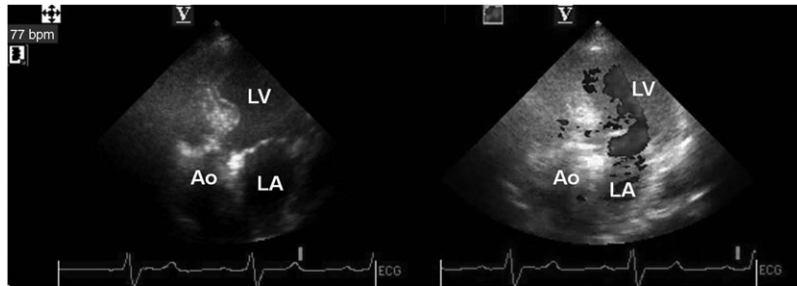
Transthoracic echocardiographic apical view of prosthetic aortic valve after successful fibrinolytic treatment. Ao, aorta; LA, left atrium; LV, left ventricle.
